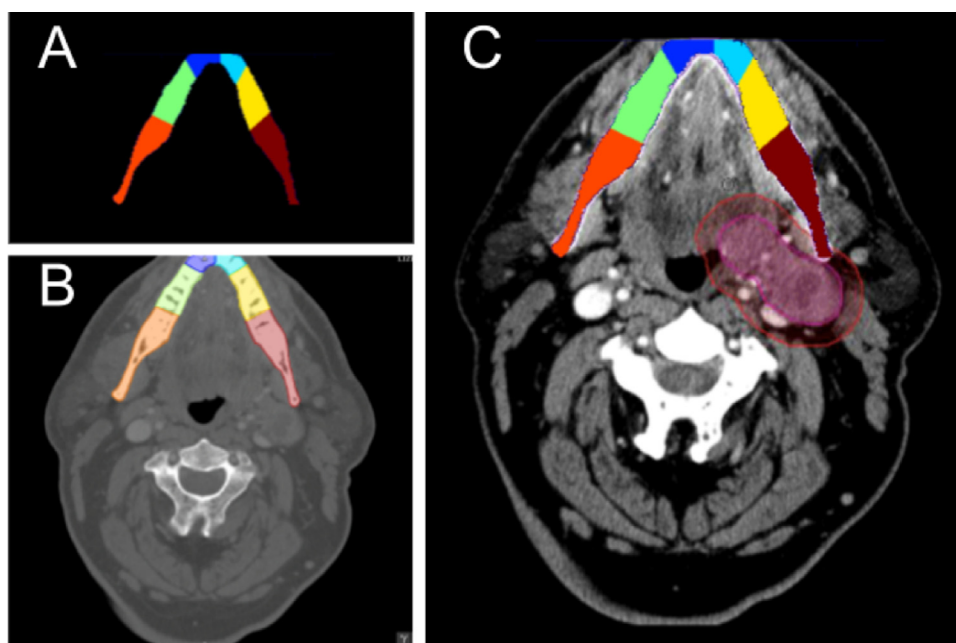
Example of minimal required contouring on a diagnostic computed tomography scan for dose prediction: (A) autocontoured mandible subsites; (B) mandible subsites on the diagnostic computed tomography; (C) gross tumor volume (dark red inner contour) and planning tumor volume (lighter red outer contour) used for dose prediction as contoured on the diagnostic CT scan.
